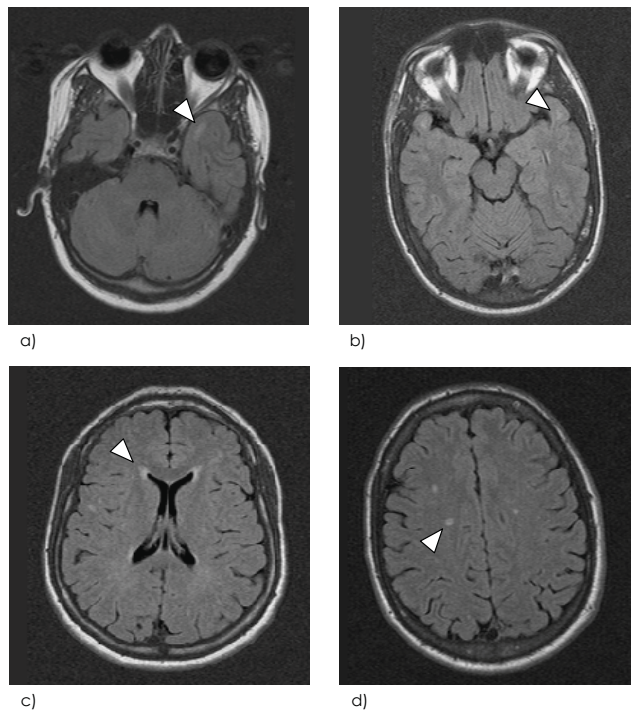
Axial FLAIR MR images in NOTCH3 mutation carriers who were 20-30 years old (a-d). Image shows areas of hyperintensity (arrowhead in a) in the anterior temporal lobe. Image shows SLLs (arrowhead in b). Image shows small ventricular caps (arrowhead in c). Image shows small areas of hyperintensity in the semiovale centre (arrowhead in d).
